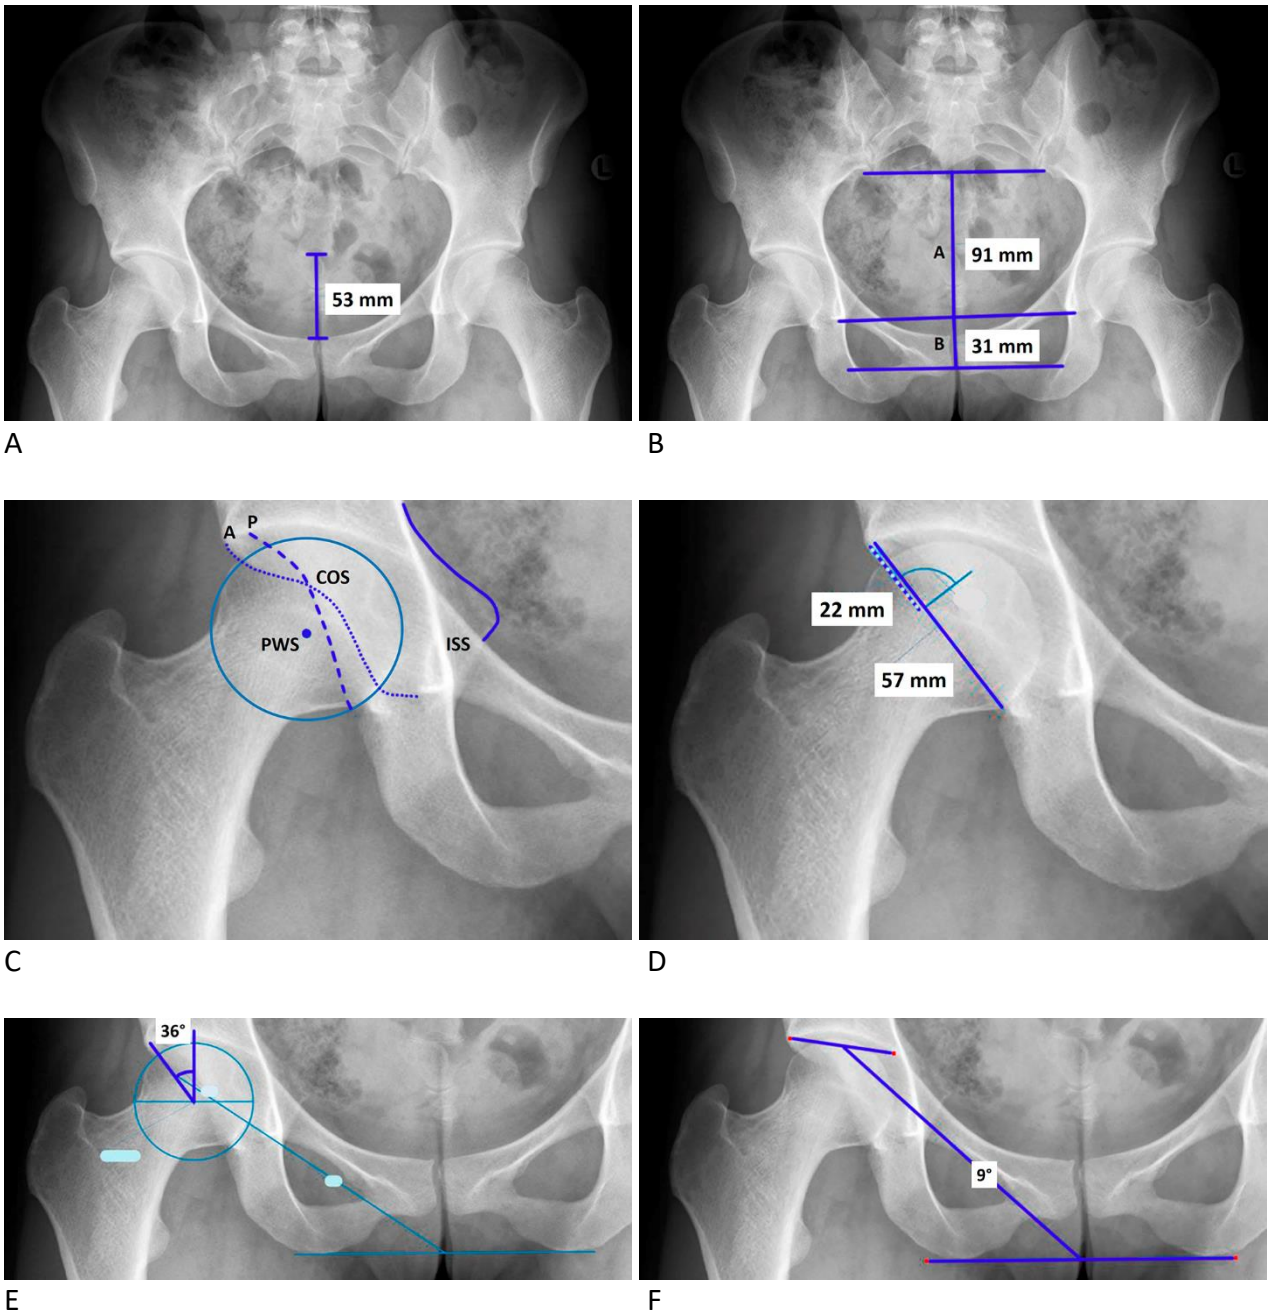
Anteroposterior pelvic radiographs in standing position (A – F)
